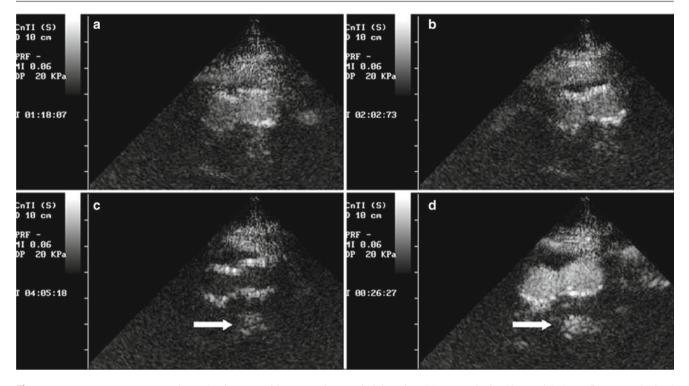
Transverse contrast-enhanced US scans with an anterior approach of a patient with an enlarging abdominal aortic aneurysm. Endoleak or other complications were not visualized at duplex US and CT angiography. (\mathbf{a} - \mathbf{c}) Images obtained after administration of an initial bolus of 2.4 ml of second-generation contrast agent show enhancement and slight contrast agent uptake 4 min after contrast agent
